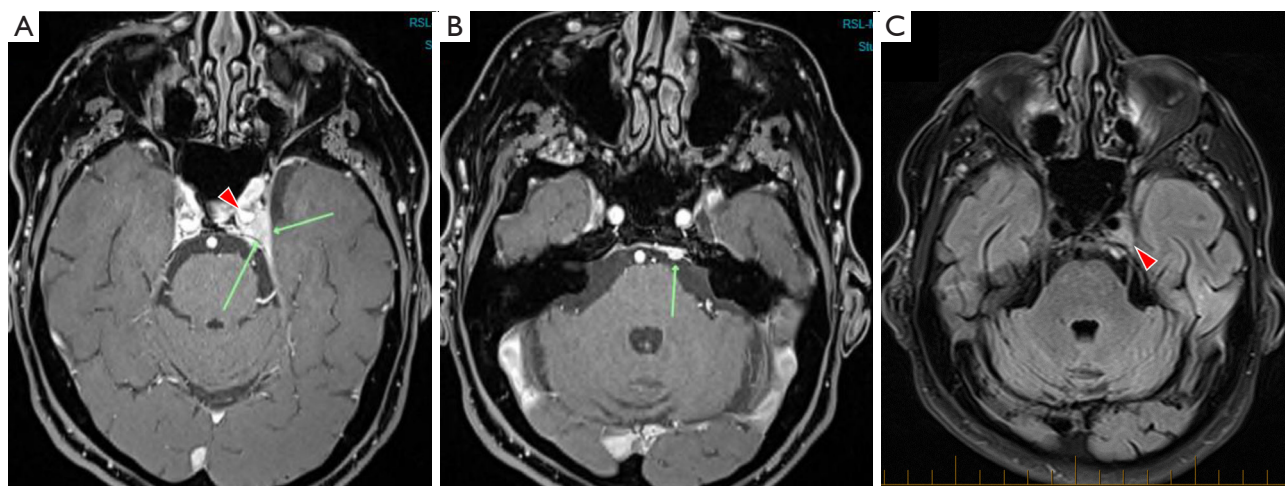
Axial MRI images showing a left cavernous sinus meningioma. (A) T1 weighted image demonstrating that the left cavernous sinus is expanded by a hypointense 7 mm maximal diameter mass (green arrows), with the left internal carotid artery displaced anteromedially (red arrowhead). (B) Gadolinium contrast enhanced T1 image showing enhancing nodular region in the inferior aspect of the left cavernous sinus (green arrow). Hypointensity of the lesion on T2 weighted images (not shown) was not consistent with schwannoma. (C) T1 weighted image demonstrating soft tissue mass in the left cavernous sinus, especially posterolaterally (arrowhead; compare asymmetry of left *vs.* right cavernous sinus). MRI, magnetic resonance imaging.
